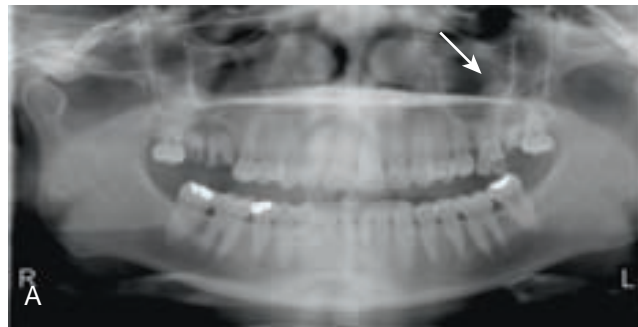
Sinus inflammatory polyp. A, Radiograph showing dome-shaped opacity (*arrow*) in the left sinus adjacent to carious left maxillary first molar and root tips of second molar. B, Mass of eosinophilic material and granulation tissue covered by respiratory epithelium with no mucous glands; many plasma cells and eosinophils (*inset*) (from A). C, Abundant eosinophilic amorphous material (from A). (A, Courtesy of Dr. Jeffrey Stone, private practice, Lowell, Mass.)
